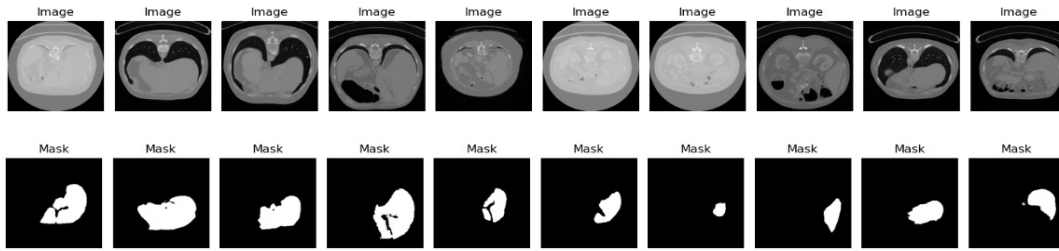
Samples of LiTS Dataset, the first set of images represents CT image, followed by corresponding liver masks.
